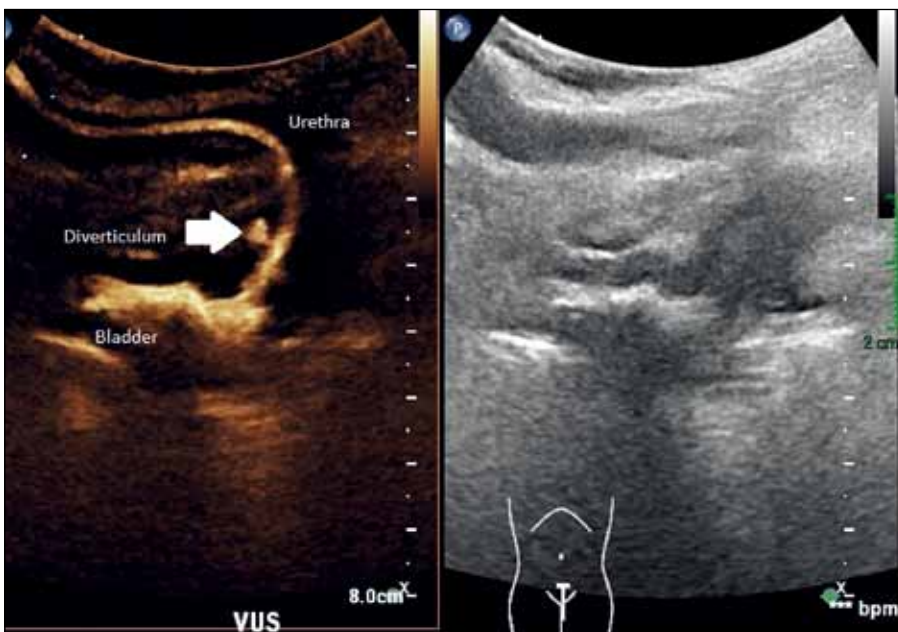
Patient D. Longitudinal contrast-enhanced voiding urosonography with transperineal interscrotal scanning during voiding. Contrast-specific harmonic imaging (left) and fundamental greyscale imaging (right) showing highly echogenic microbubbles passing from urinary bladder into urethra during voiding. A 5-mm contrast-filled outpouching at the anterior aspect of the prostatic urethra represents prostatic urethral diverticulum (white arrow) with normal calibre of the anterior and posterior urethra, suggesting absence of urinary flow obstruction.
